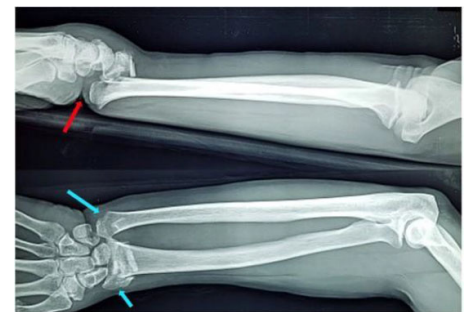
Preoperative right forearm PA/Lateral X-rays showing the significant dorsal displaced comminuted distal radius fracture with ulnar styloid avulsion (the blue arrows). Volar skin tenting demonstrated from a lateral view indicates the risk of median nerve compression (the red arrow).
